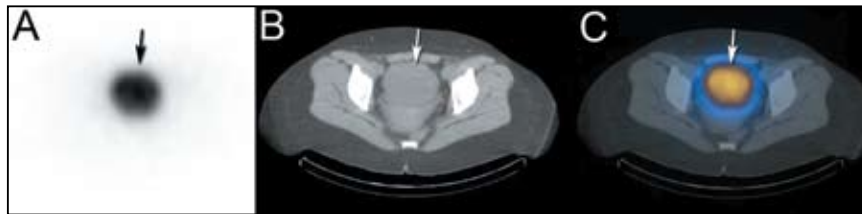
Axial SPECT (A), CT (B), and fused SPECT/CT (C) images show intense uptake in a round mass anterior to the pelvis (black arrow and white arrows, respectively).
